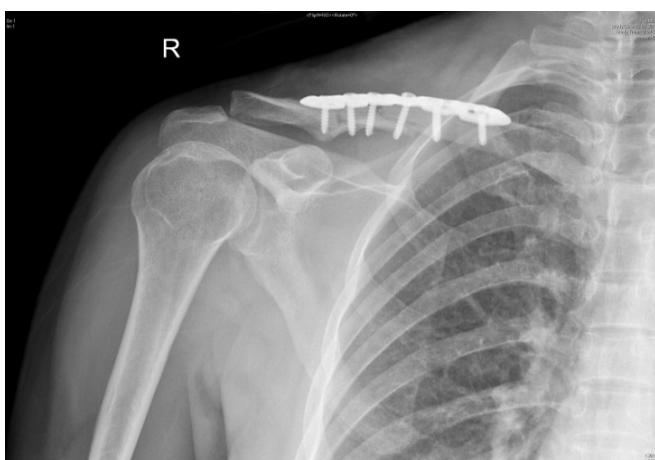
42 years woman's postoperative shoulder AP x-ray image showing that clavicle comminuted fracture that fixed anatomic plate
